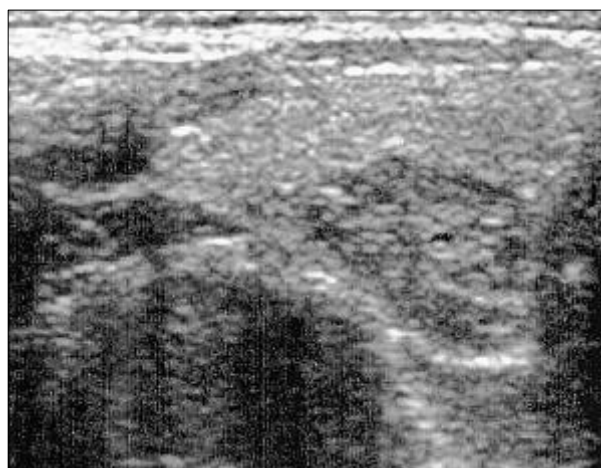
Adenomatous hyperplasia in a 58-year-old woman. A 15 mm sized hypoechoic mass was noted in the right lobe of the thyroid. The result of FNAB was benign (adenomatous hyperplasia). Follow-up sonography, after 26 months, showed no interval change.
